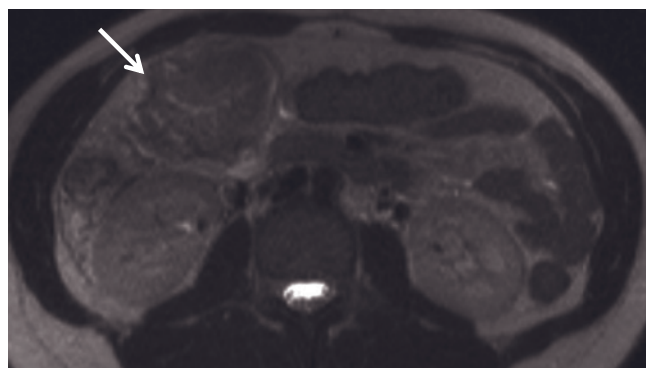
Small bowel intussusception. T2-weighted SS-ETSE (a) and T2-weighted fat-suppressed echo-train spin-echo (b) images in two patients. In the first patient, the T2-weighted image (a) provides clear definition of the bowel-within-bowel appearance (arrow) of intussusception. In the second patient (b), respiratory and bowel motion degrades the majority of the peritoneal cavity. However, the dilated, relatively fixed, hypotonic loop of the intussusciens (long arrow, b) is relatively well shown. The intussusceptum (short arrow, b) is clearly shown, and its mesentery (open arrow, b) is also appreciated. In this second patient adequate visualization of the intussusception occurred in this non-breath-hold study because of the hypotonicity of the involved bowel segments. Coronal (c) and sagittal (d, e) T2-weighted SSETSE images in a third patient. The bowel-within-bowel appearance (arrows, a-c) is clearly demonstrated. (Courtesy of N. Cem Balci, Florence Nightingale Hospital, Istanbul, Turkey). Intussusceptions
